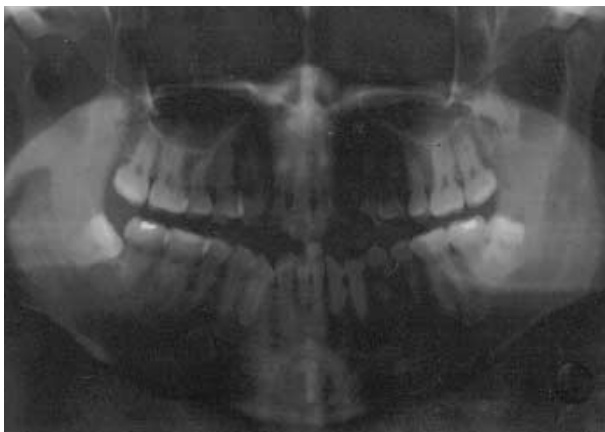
There is no remarkable bony resorption around left lower third molar in panoramic X-ray view.
